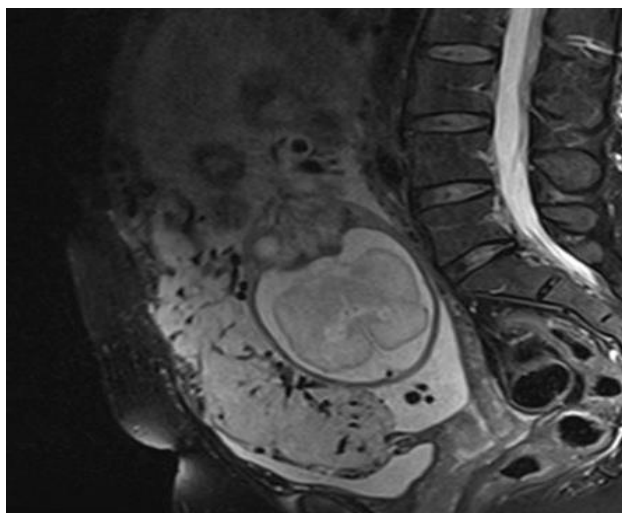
MRI of anterior placenta percreta in scar of cesarean section – 29 week of gestation
